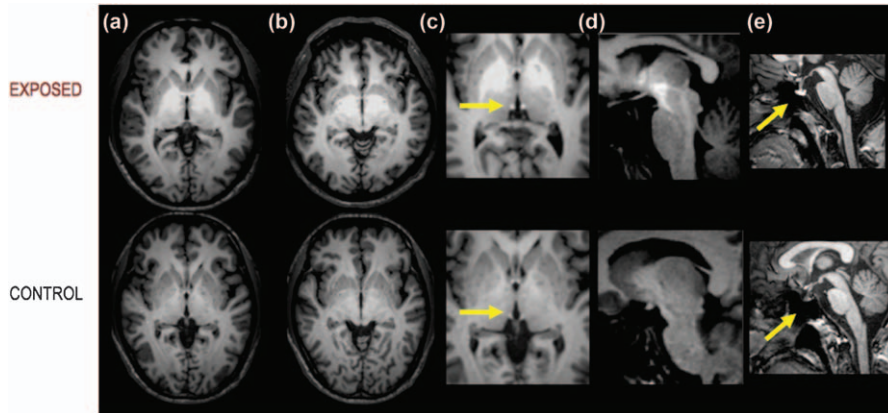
T1*-weighted MRI images from a Mn-exposed smelter (top row) and a non-exposed control subject, showing hyperintensities in (a) the globus pallidus and part of the thalamus, (b) subthalamic nucleus, (c) pineal stalk, (d) medial cerebral peduncle and (e) pituitary gland.⁵⁰ (Reproduced with permission from Dydak *et al.*, *Proc. Intl. Soc. Mag. Reson. Med.*, 2011, 19, 1428).
